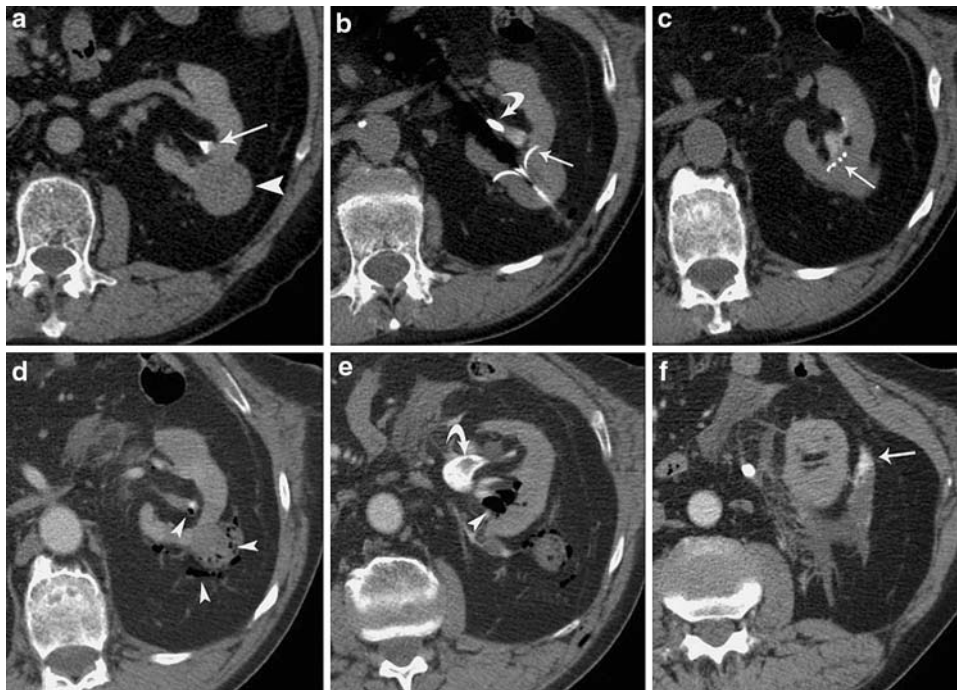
Images obtained in a 76-year-old patient with chronic renal failure and a 35-mm exophytic tumor of the left kidney. (a) Contrast-enhanced CT image showing the tumor (arrowhead), which was located 3 mm from the closest calyx (arrow). (b), (c) Contrast-enhanced CT images showing the RFA electrode placed in the tumor. The electrode tines were approximately 2 mm from two different calyces (arrows). A perfusion of cooled saline was done during the ablation through a ureteral catheter placed in the closest infundibulum (b; curved arrow). (d), (e), (f) Contrast-enhanced CT images obtained
